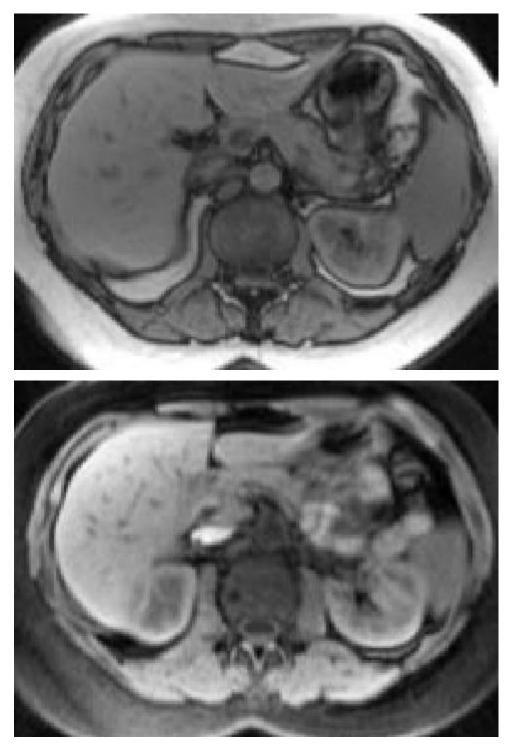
MRI of patient W., 32 years old, with pain attacks in the upper abdomen, dyspeptic syndrome. It aims to survey the clinical diagnosis: postcholecystectomical syndrome, CP: a - T2-WI in the coronal projection visualized hepatopancreatoduodenal area: horseshoe of duodenum (D, the head of the pancreas, common bile duct (CBD) and MPD), *b*, *c*, *d* - T2-WI, T1 and T1-WI-WI with fat-suppression in the axial plane, the pancreas has isointensive signal liver and spleen, its dimensions correspond to age norm, contours precise, equal.
